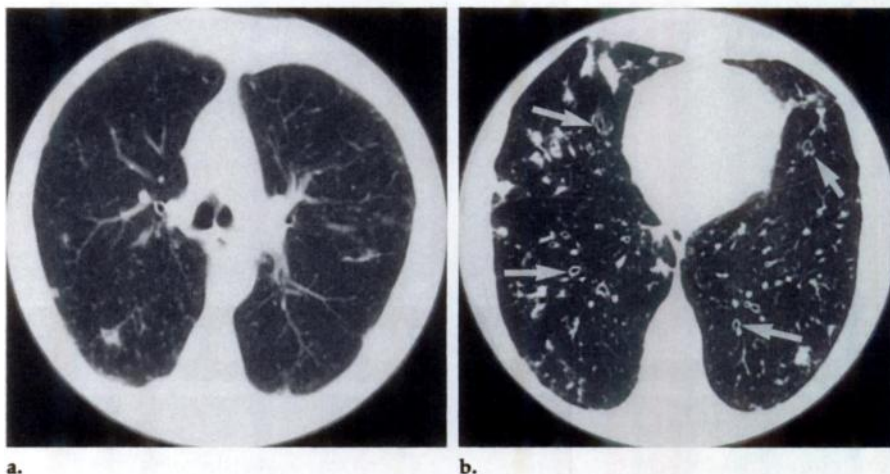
(a) Conventional CT scan and (b) HRCT scan obtained in a 69-year-old woman. (a) Nodular infiltrate is seen in the superior segment of the right lower lobe and in the left upper lobe. (b) HRCT scan at a level approximately 3 cm caudal to that in (a) shows bronchiectasis (arrows) in all lobes.
